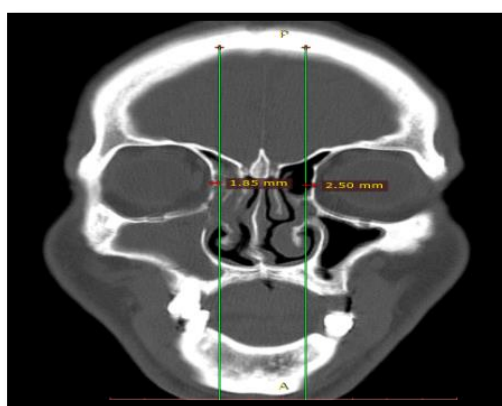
coronal CT showed: on right side grade 2 polypi with lamina papyracea (LP) type 1. on the left side grade 0 polyposis with LP type 3.
